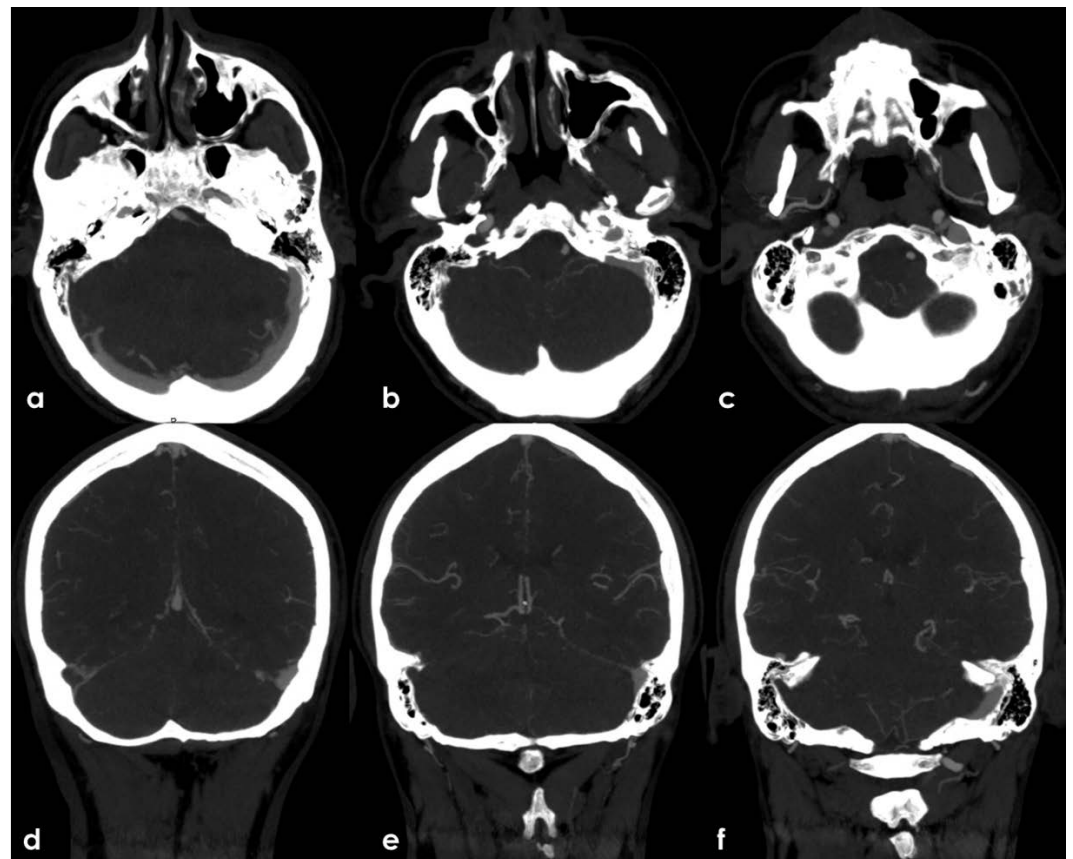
Arch-to-vertex CTA with MIP reconstructions. The lack of contrast filling of the right TS (from its middle segment), SS and IJV in comparison with the regularly contrast filled contralateral segments is showed in axial cranio-caudal slices (a-c) and in coronal posterior-to-anterior slices (d-f).
